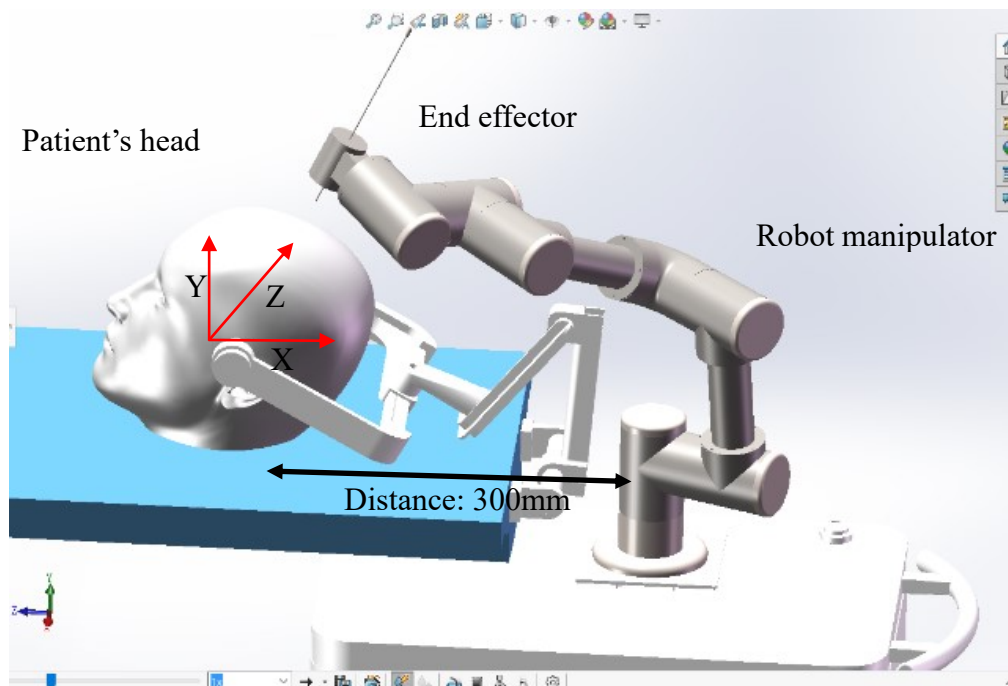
3D model of the MRI-guided robot placement during operations
